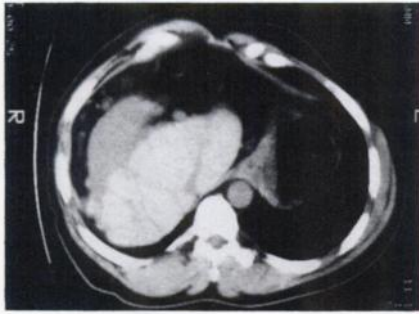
Right lateral decubitus CT of the liver shows small multilobulated liver with different tissue densities consistent with cirrhosis.
